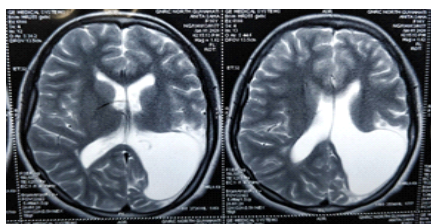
T2 Axial MRI Sequence showing large single intraparenchymal cyst present in left Parieto-occipital region, communicating with the ventricular cavity.
